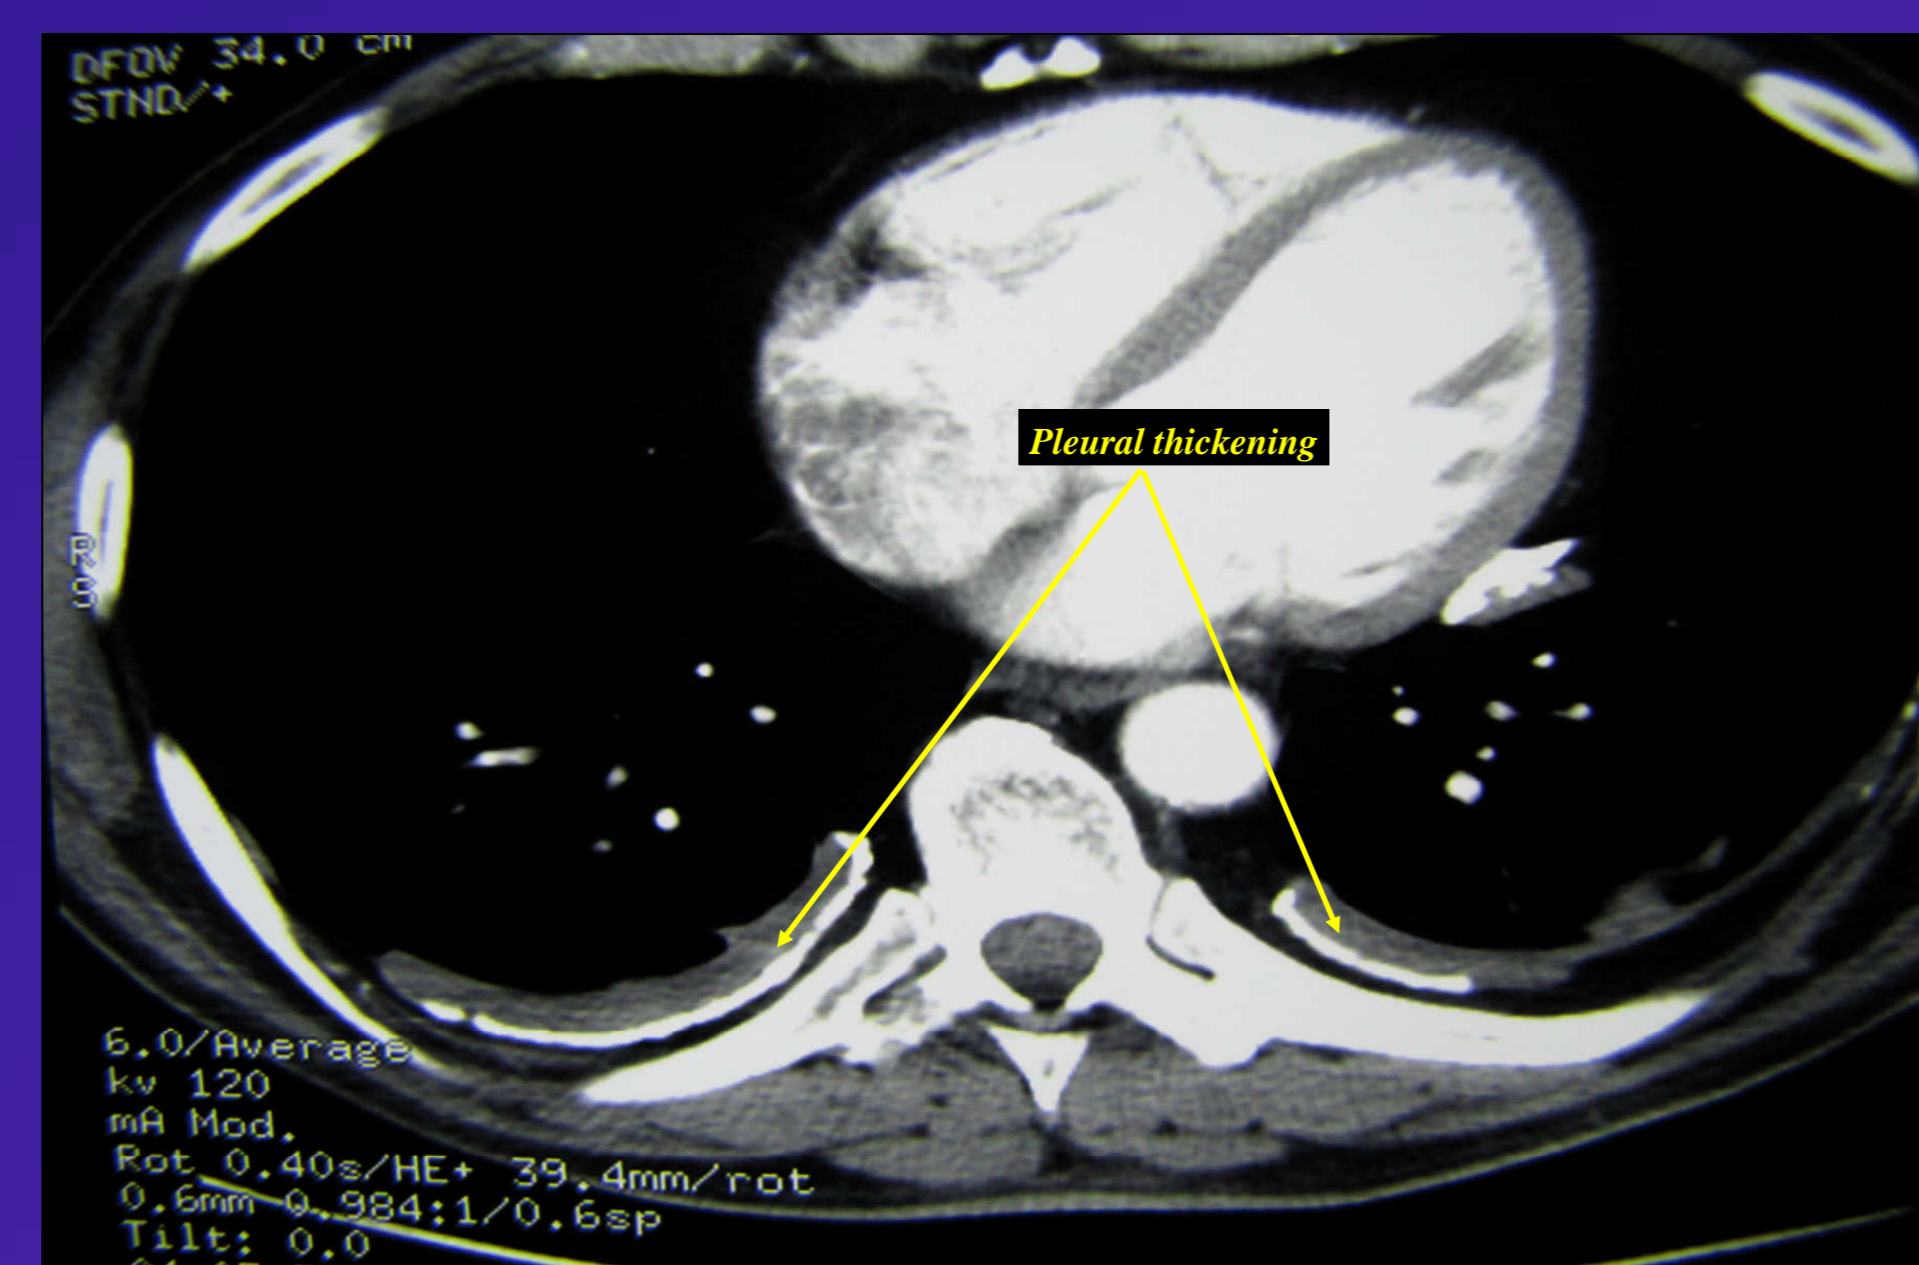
CT chest scan indicating pleural thickening.
